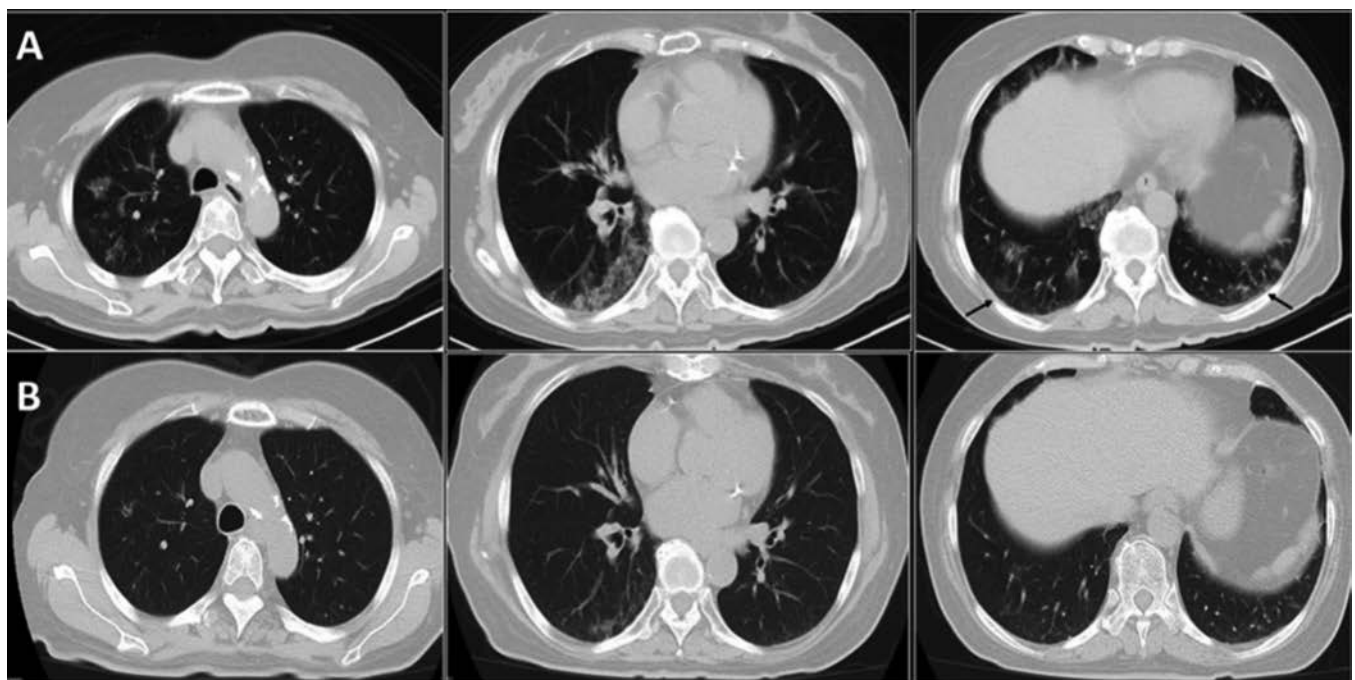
CT scans of a patient with SSc and COVID-19 at presentation and during follow-up. (A) Multiple, bilateral GGO, some with rounded morphology, with a predilection for lower lobes and a peripheral predominance. These features are consistent with a typical radiologic appearance of COVID-19 pneumonia. However, the coexistence of NSIP with SSc cannot be ruled out, especially at lung bases, where GGO are subpleural and symmetric (black arrows). (B) After 8 weeks, GGO are decreased in both extension and density. COVID-19: coronavirus disease 2019; CT: computed tomography; GGO: ground-glass opacities; ILD: interstitial lung disease; NSIP: nonspecific interstitial pneumonia; SSc: systemic sclerosis.
